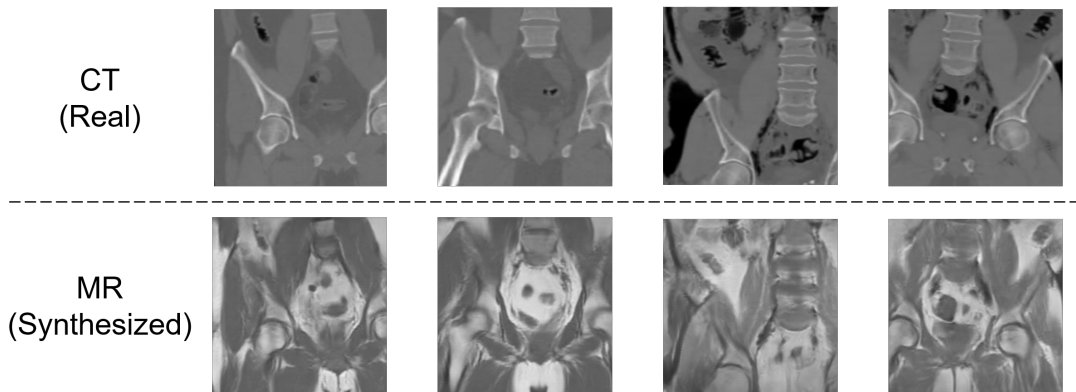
CycleGAN CT generator ( $G_{MR}$ ) training results (training size: 4000, with implementation of structural consistency loss  $\mathcal{L}_{sc}$ )
